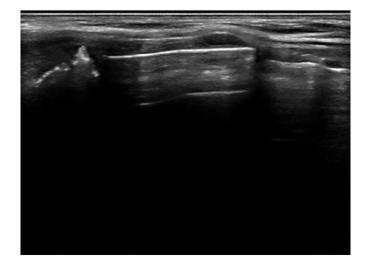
Sonographic appearance of the cricothyroid membrane.
